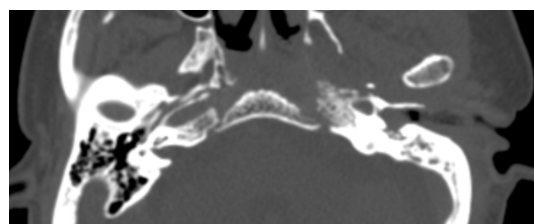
Preoperative temporal bone CT scan
